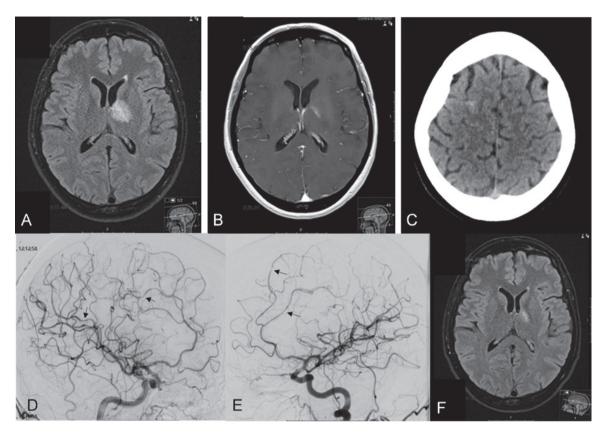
Brain MRI. Large MS lesion in genu of left internal capsule extending to anterior part of thalamus (a, b). Brain CT: small amount of SAH in right superior frontal sulcus (c). DSA: multiple narrowings on distal ACA and MCA branches on both sides (d, e). Follow up brain MRI after corticosteroids: reduction in size of MS lesion in genu of left internal capsule extending to anterior part of thalamus (f).
